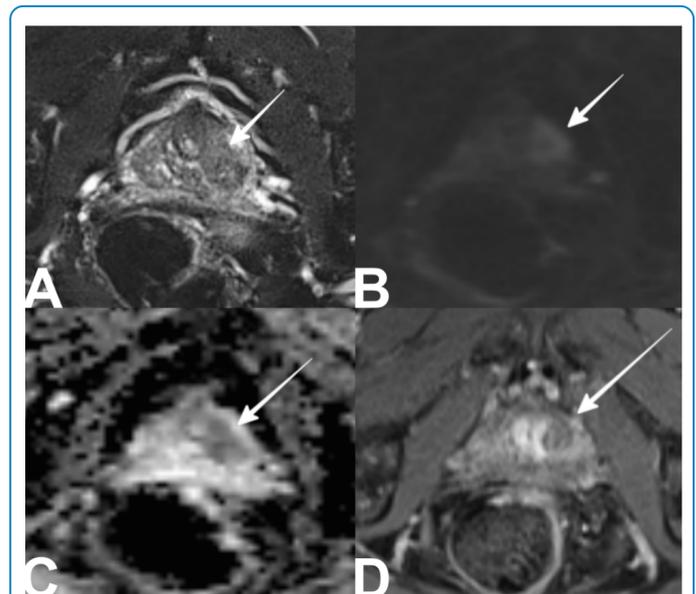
A. Axial T2-weighted images showed a focal and ill-defined low-signal intensity lesion in the left anterolateral peripheral zone close to the base (arrow). B-C. Diffusion-weighted images and apparent diffusion coefficient maps show the diffusion restriction of the lesion (arrow). D. Axial contrast-enhanced images show an early and prolonged ring enhancement of the lesion (arrow).
